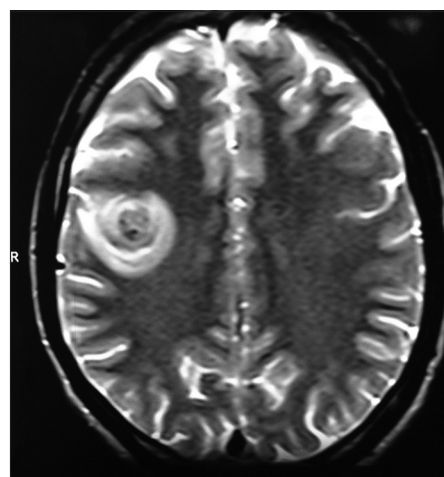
Magnetic resonance imaging brain T2-weighted image axial section showing the well-defined lesion with hypointense center and with peripheral hyperintensity in the right posterior frontal region
